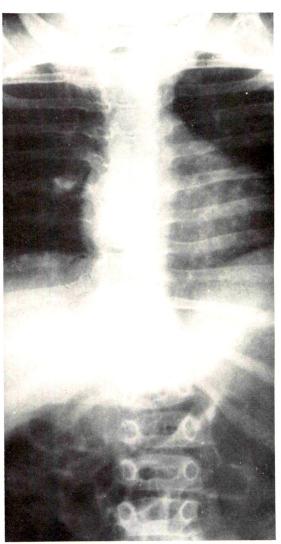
Case I. Aged 3 years, 9 months. Anteroposterior roentgenogram of the spine showing moderate but definite structural scoliosis.
